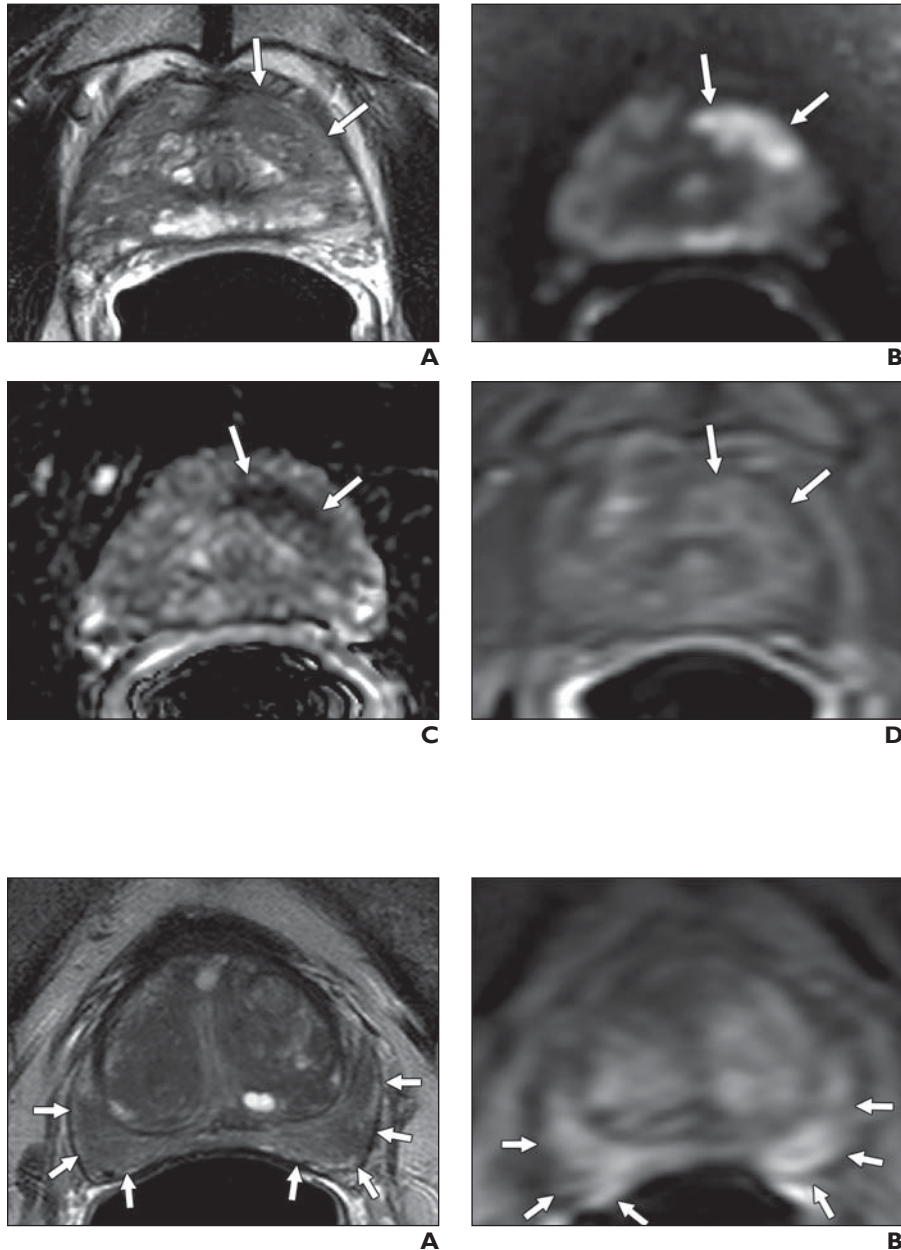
67-year-old man with serum prostate-specific antigen value of 17.20 ng/mL who was referred for multiparametric MRI (mpMRI); 3-T mpMR images obtained with endorectal coil show classic Prostate Imaging Reporting and Data System (PI-RADS) 5 lesion measuring 2.4 cm in left apical-mid anterior peripheral zone. A–D, Lesion (arrows) is hypointense with ill-defined borders on axial T2-weighted image (A), hyperintense on high-b-value DW image (B), hypointense on apparent diffusion coefficient map (C), and enhancing on dynamic contrast-enhanced MR image (D). Overall PI-RADS score of 5 was given to this lesion. At pathology, lesion was found to include Gleason 3 + 4 prostate cancer.
